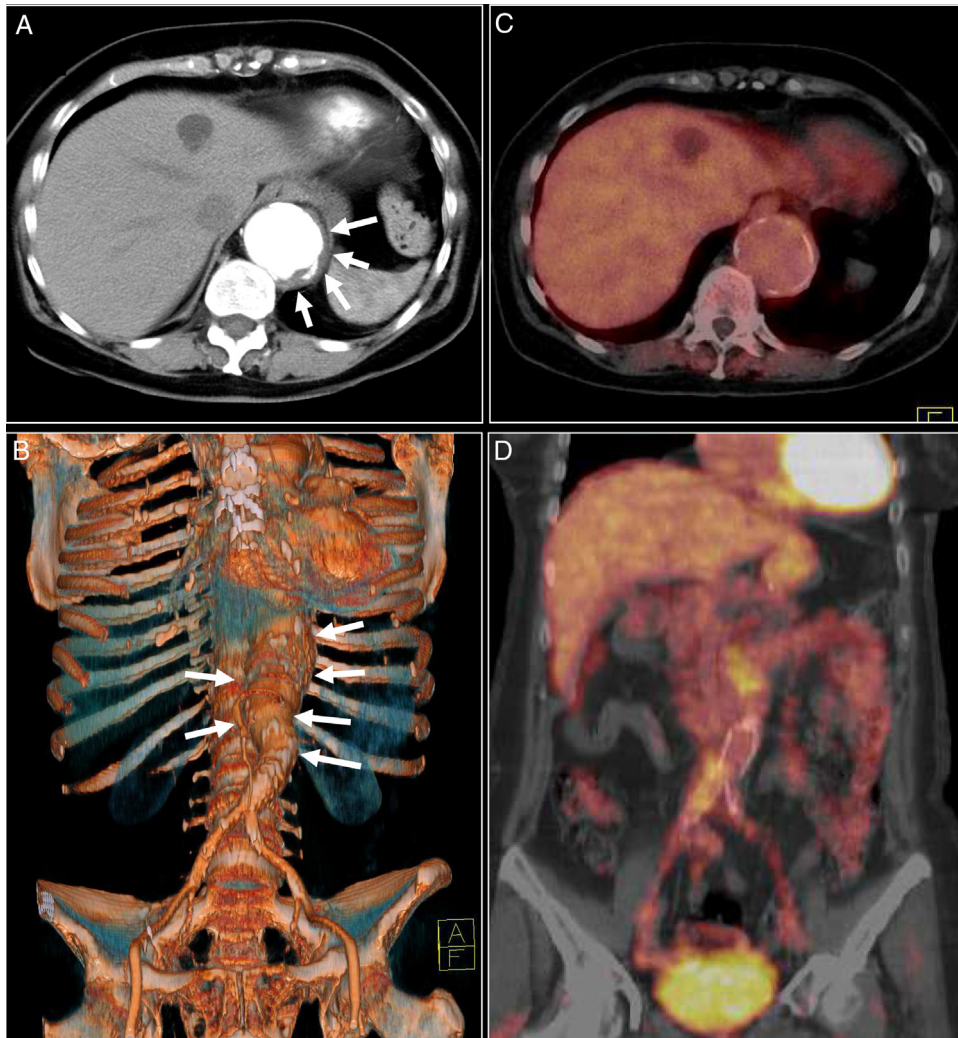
Axial CT slice with intravenous contrast (A) showing a thickened vascular wall, that forms a hypodense "cuff" surrounding the lumen (arrows) and the rendered volume (B) in which dilation of the abdominal aorta can be seen (arrows) that progressively decreases until the iliac bifurcation. The fusion images (C and D) show the correspondence of these findings. Note particularly the absence of inflammatory activity in the first section of aortic dilatation and thickening of its wall and the focus of activity corresponding to the root of the right common iliac artery.
